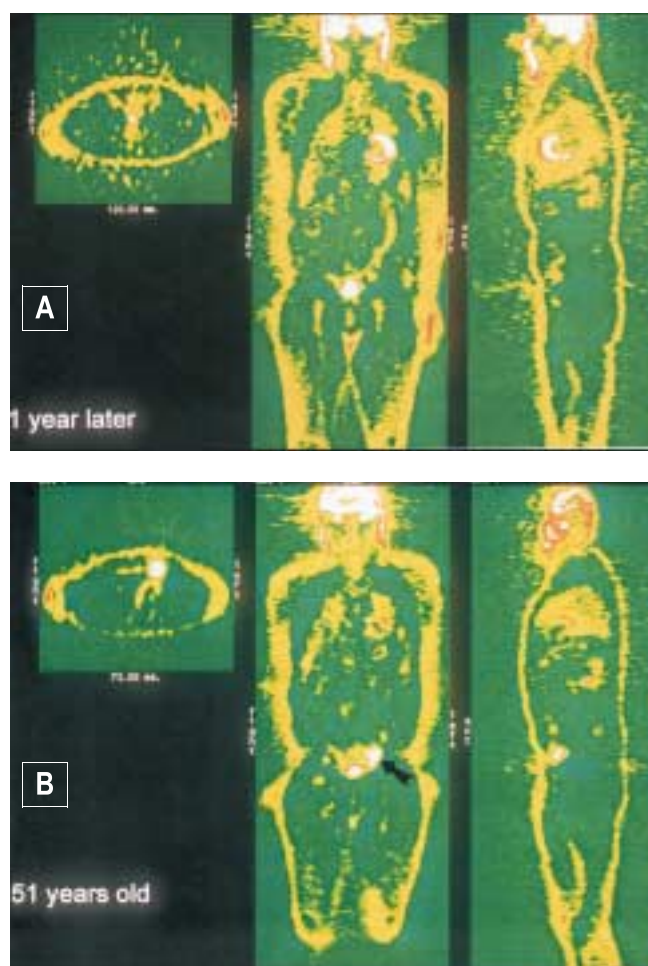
A patient with metastatic melanoma and a left pelvic metastatic deposit. Positron emission tomography images with ^{18}F FDG before IL-2 therapy [A, arrow] and a year after terminating treatment [B].
